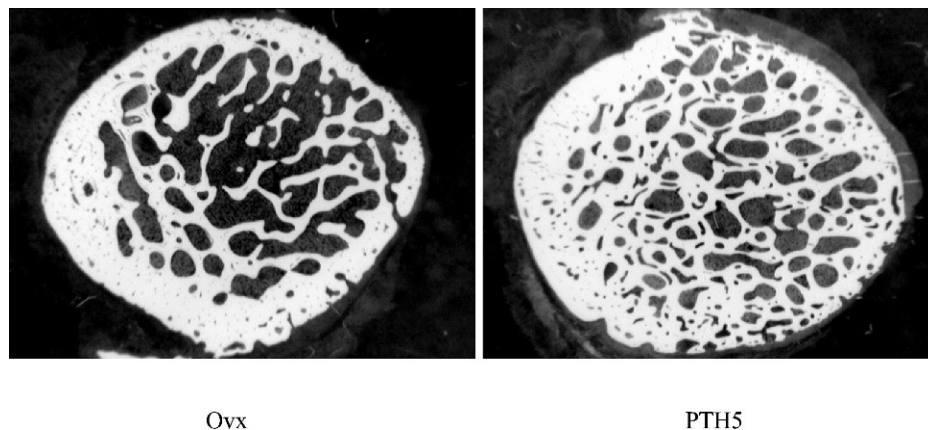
μ CT images of the femoral neck after 18 months of treatment. Teriparatide treatment (right) seemed to increase trabecular area and trabecular number. Treatment seemed to increase tunneling of thickened trabeculae and the cortex, which was not different from OVX (left) with withdrawal, especially for PTH1W. Teriparatide also increased cortical width and area in femoral neck.
